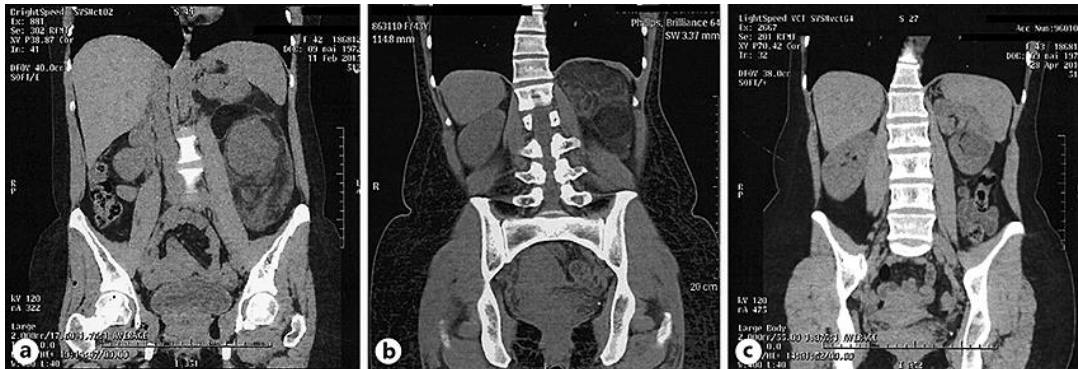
a Abdominal computed tomography (CT) before the first surgery. b Abdominal CT after local recurrence. c Abdominal CT during cure follow-up.
